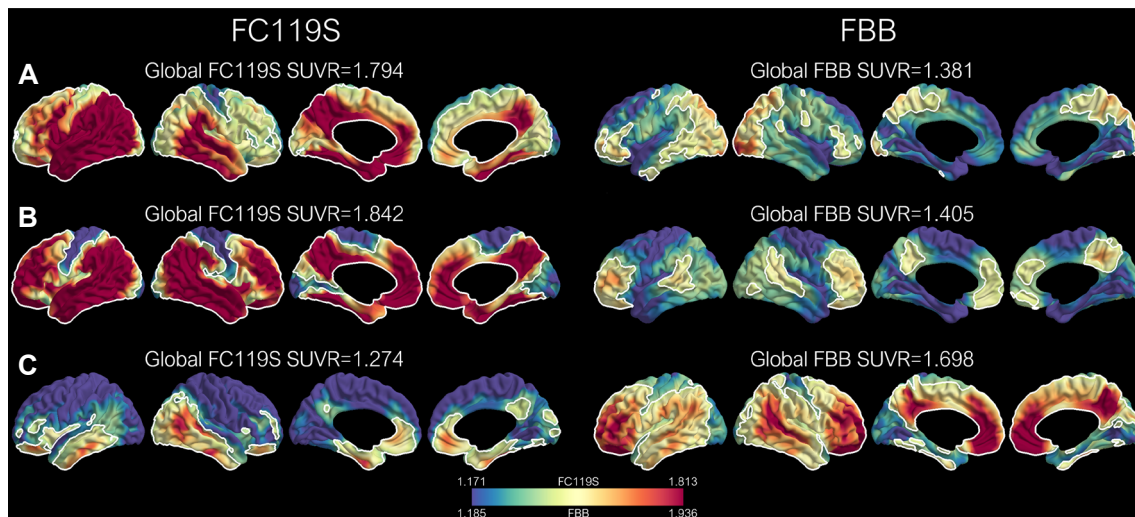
Vertex-wise SUVR values in the two patients with FC119S-positive but FBB-negative scans (participants A and B), and the patient with FC119S-negative but FBB-positive scans (participant C). The red-colored numbers are the time intervals between the FC119S-PET and FBB-PET scans. The time interval was calculated as follows: (acquisition time of FC119S-PET)-(acquisition time of FBB-PET). The color scale is displayed using the 5th to 95th percentiles of each tracer. FBB, ^{18}F -florbetaben; FC119S, ^{18}F -florapronol; PET, positron-emission tomography; SUVR, standardized uptake value ratio.
